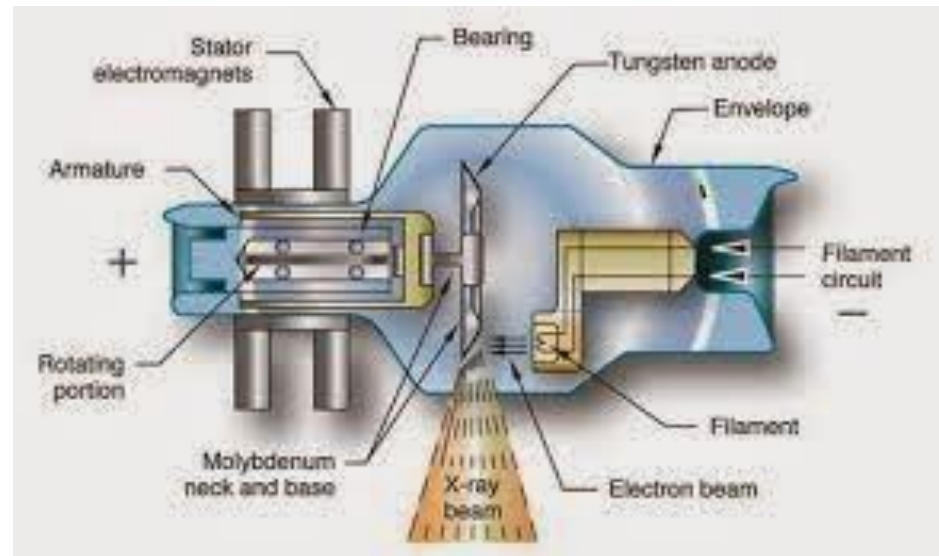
Principal parts of a rotating anode x-ray tube.
